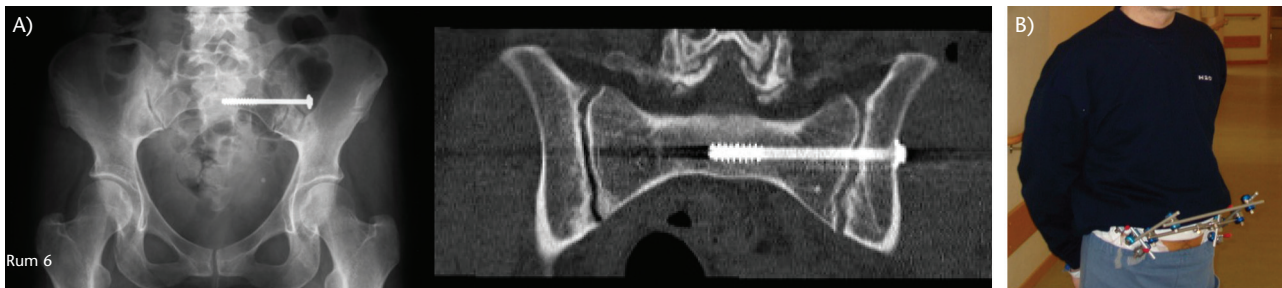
Previous approaches. (A) Unilateral fusion of the sacro-iliac joint (SIJ): radiograph and computed tomography scan control. (B) External frame for sacro-iliac fusion.
